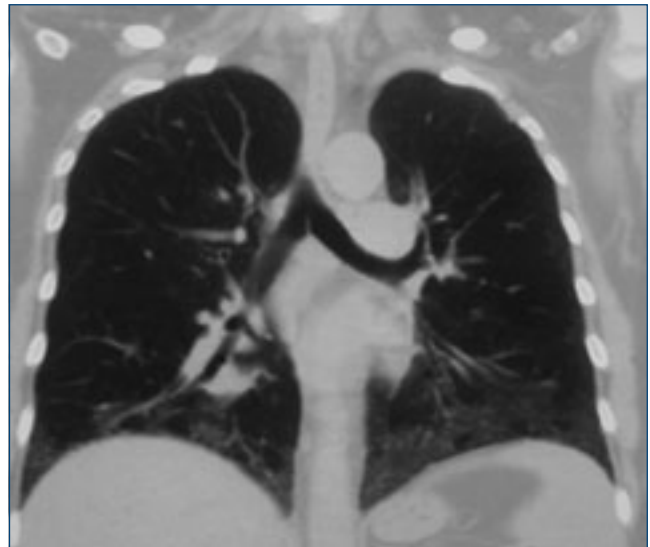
HRCT after 7 months of steroid therapy showed the persistence of ground glass opacities in the lower lobes
